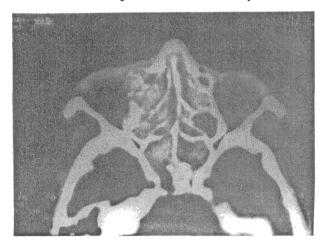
Axial CT of paranasal sinus showing mass of variegated consistency involving bilateral ethmoids and sphenoid sinuses with intact inter sinus septa. The mass has destroyed lamina paparecea without infiltrating the surrounding tissue (non-invasive, destructive type of fungal sinusitis).
